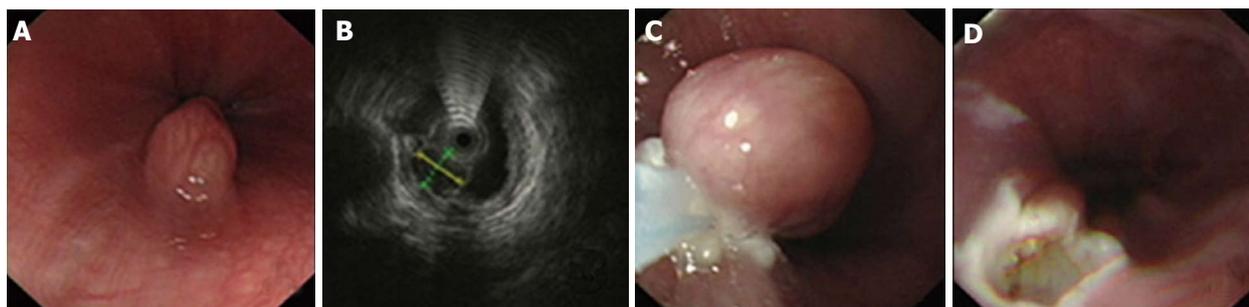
An esophageal leiomyoma treated by snare electrosection. A: An elevated lesion in the lower esophagus; B: A homogeneous, hypoechoic mass ($1.0 \times 0.7 \text{ cm}^2$) with a regular border originated from muscularis mucosa, which was diagnosed as a leiomyoma by endoscopic ultrasonography; C: The tumor was snared at the base, and then it was resected by snare electrosection; D: Postoperative wounds.
